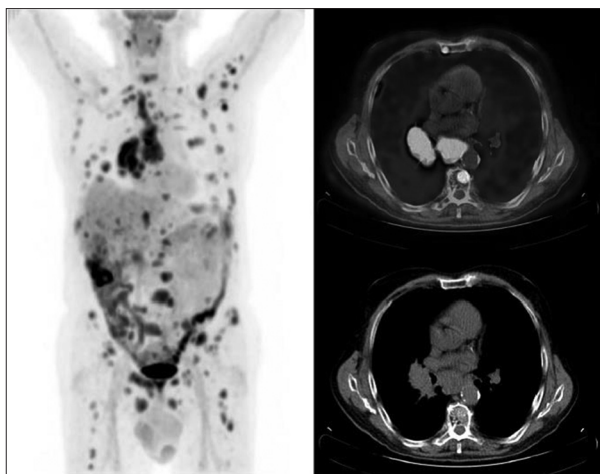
A patient shown in this image was diagnosed by bronchoscopy and endobronchial ultrasound with non-small cell lung cancer. “No signs of distant metastases were observed on computed tomography of the chest and abdomen, or in the biochemical analysis.” Nevertheless, positron emission tomography-computed tomography identified numerous bone metastases. This required the treatment method to be modified from curative-intent to palliative
